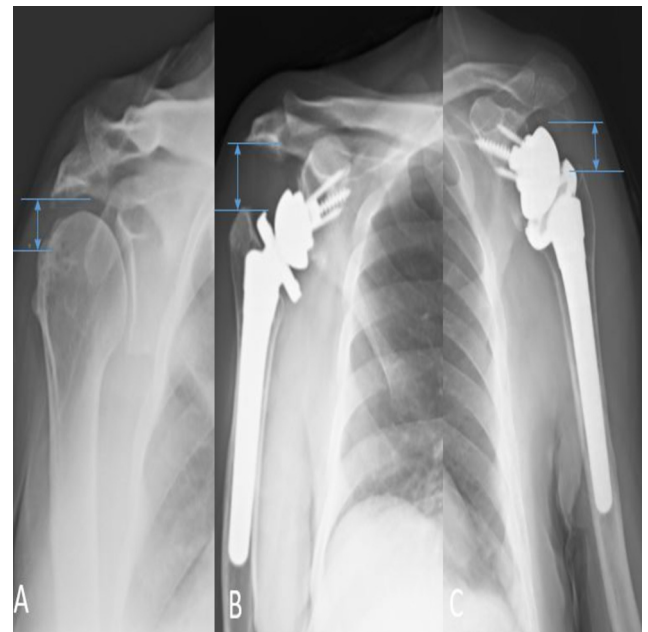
A. Preoperative acromiohumeral distance. B. Postoperative acromiohumeral distance change in patient without os acromiale. C. Postoperative acromiohumeral distance change in patient with os acromiale. Postoperative shoulder x-ray show os acromiale migrate distally.
